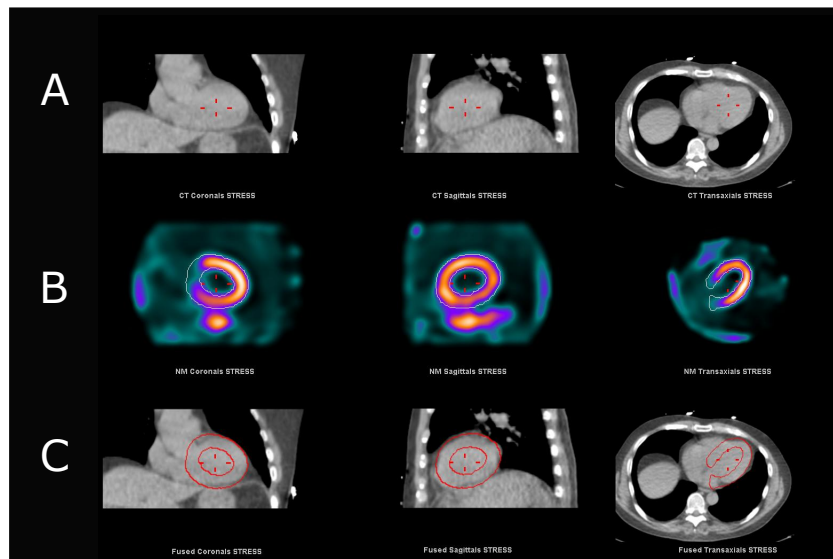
The co-registration window in Xeleris when performing attenuation correction on a patient measurement. A: The CT image. B: The NM image. C: A fusion of A and B showing how the co-registration will be performed.
